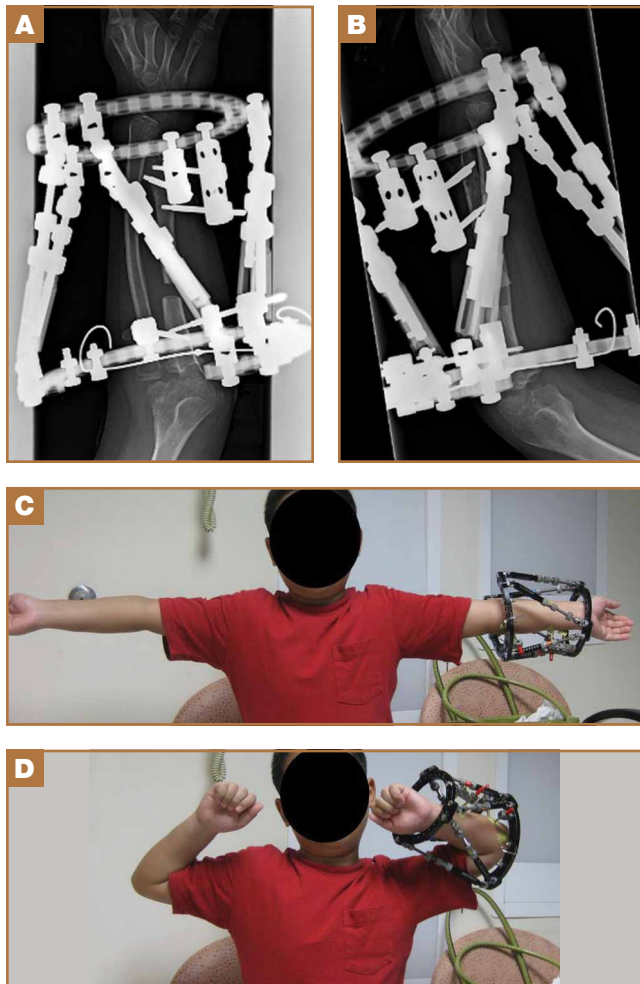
Radiographs and clinical photographs of left forearm after index procedure. (A) Anteroposterior and (B) lateral radiographs show placement of external fixator with ulnar diaphyseal osteotomy. (C,D) The patient's elbow range of motion improved to 0° to 135°.
